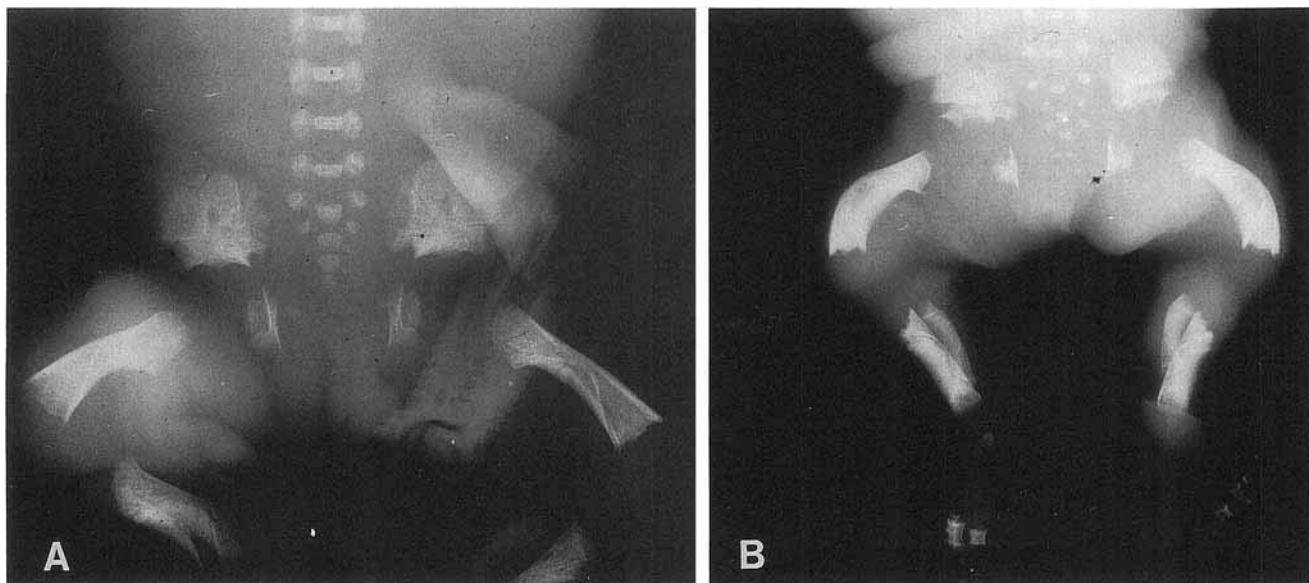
Radiographs with higher magnifications of the lower limbs of cases 1 (A) and 2 (B) with limb shortness, metaphyseal irregularities and the "straighter" type of long bones of case 1 when compared to the more "curved" type of long bones in case 2.
